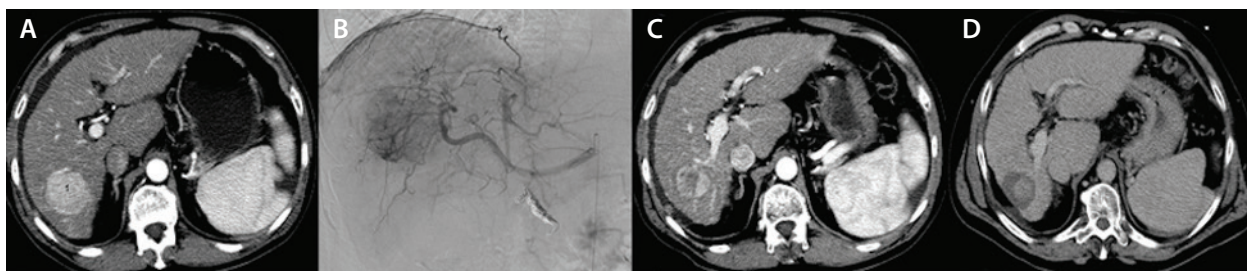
Right liver HCC successfully downstaged with Y-90 SIRT and treated with curative microwave ablation. Arterial phase CT with a large, hypervascular right liver HCC (A). An angiogram was obtained during selective right segmental radioembolization (radiation segmentectomy) (B) with follow-up after Y-90 contrasted-enhanced CT demonstrating an interval decrease in tumor size and increase in necrosis (C). A 1-year follow-up CT was performed after radioembolization and curative microwave ablation of the tumor, showing no evidence of recurrent disease (D).
